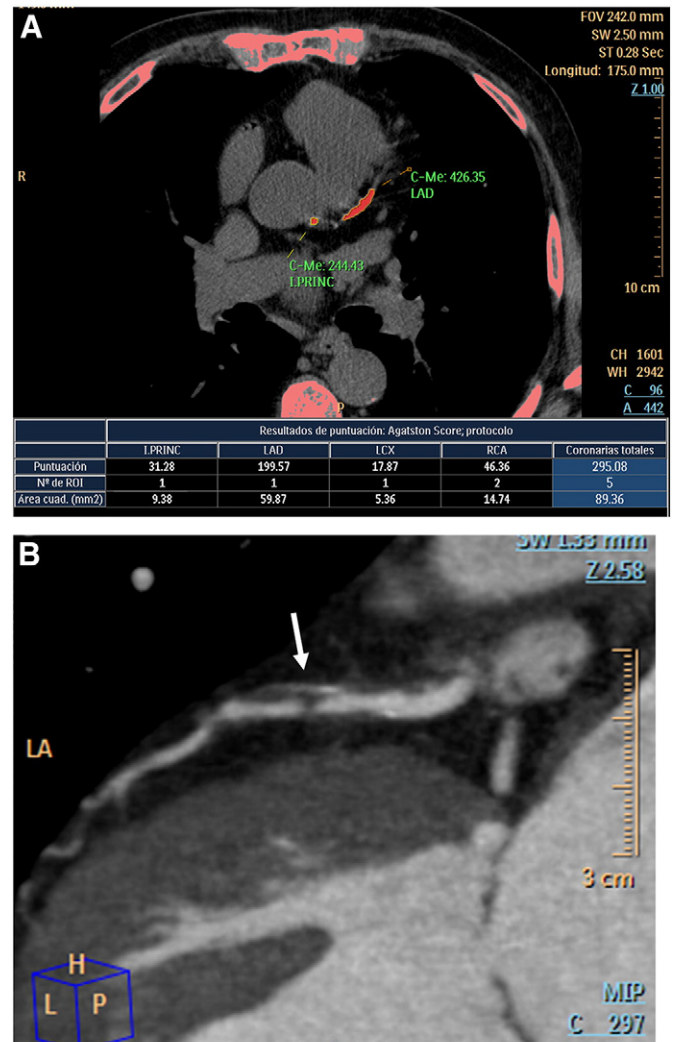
Multidetector computed tomogram findings in a 56-year-old man with chest pain of uncertain cause. The coronary calcium score was 295 (panel A). Contrast-enhanced MDCT showed a severe luminal stenosis in the proximal left anterior descending coronary artery (panel B, arrow).
